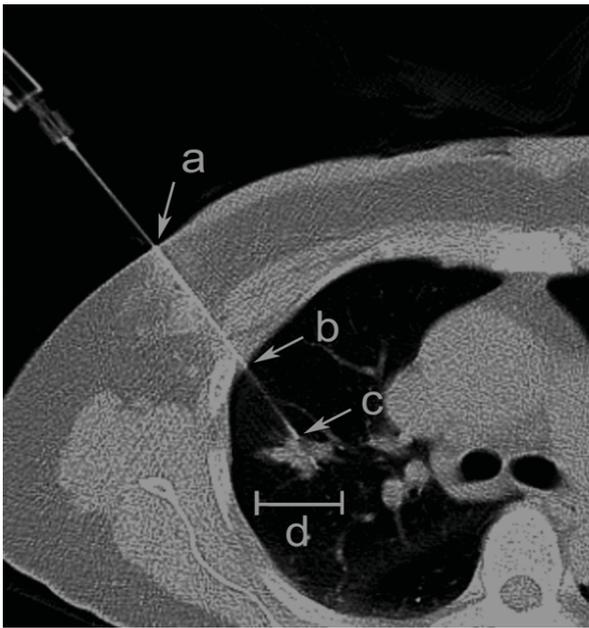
A 68-year-old male patient with adenocarcinoma in the right upper lobe diagnosed at CT-guided thoracic biopsy. The lesion depth was measured from the surface of the skin to the nearest edge of the lung lesion along the needle path (distance a to c). The traversed lung length was measured from the point of pleural puncture to the nearest edge of the lung lesion along the needle path (distance b to c). The lesion size was measured along the maximum long-axis diameter (d).
